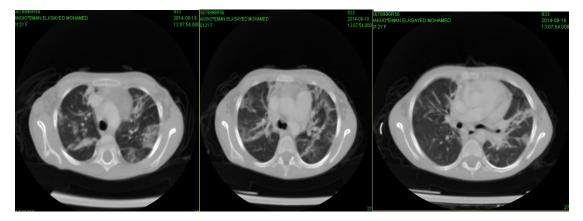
Chest CT showed bilateral pulmonary infiltrates with lower lobe predominance some of them are triangular shaped and pleural based.
